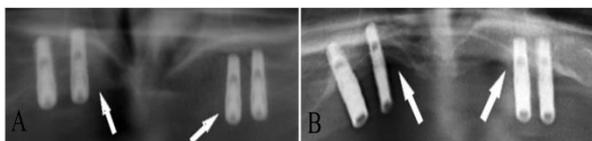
A. Post-operative radiographic image of a patient with removable prosthesis. B. Radiographic image of the patient during the follow-up period. Increased marginal bone loss around the implants (white arrow).
